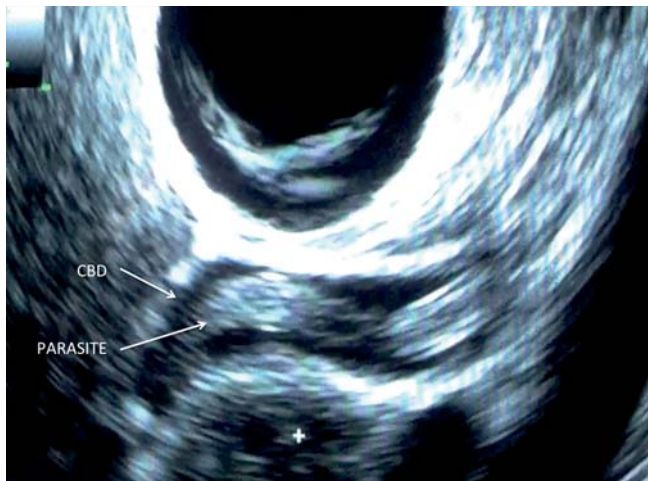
Endosonographic view of *Ascaris lumbricoides* parasite inside the common bile duct (CBD).
